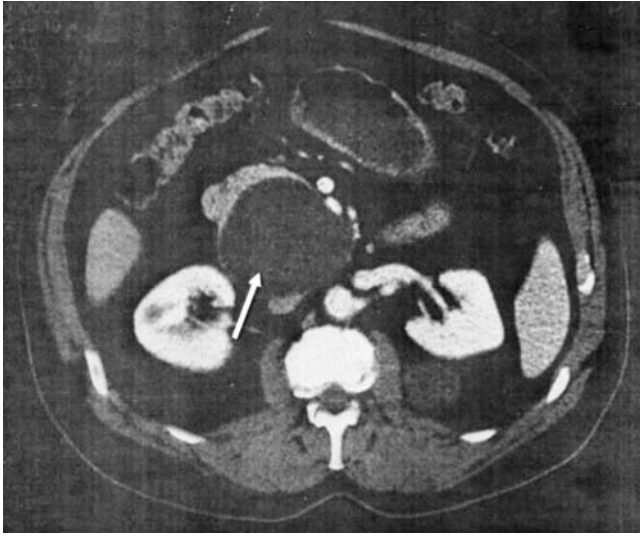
Abdominal CT performed on a 69-year-old healthy man who had a palpable abdominal mass detected on routine physical examination. The mass (*arrow*) was homogeneous in character and was initially presumed to be a pseudocyst. Pylorus-preserving pancreaticoduodenectomy was performed, revealing an 8.5-cm mucinous cystic neoplasm without malignancy.
